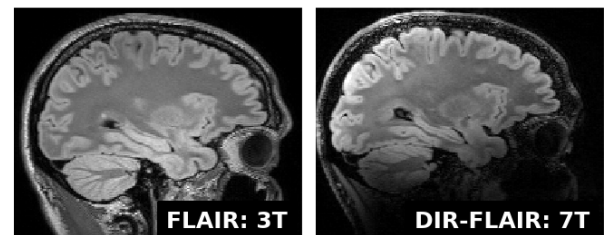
Sagittal FLAIR images at 3 and 7T: Even down to the cerebellum inversion is working and generating a typical FLAIR contrast.
